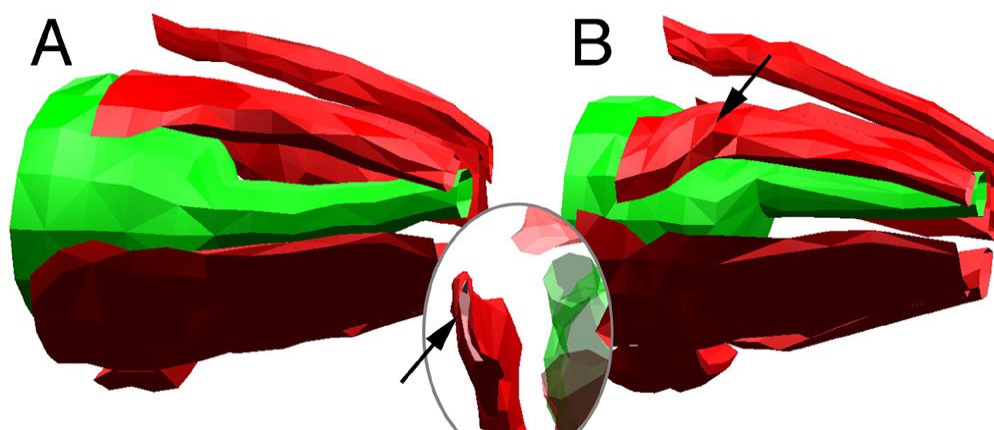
Patient TS, 3-D MRI reconstructions of extraocular muscle paths in primary gaze. A: Preoperative MRI scan shows left SO and left LR atrophy typical of chronic denervation. Note in inset, posterior view showing unusually thin LR. B: Postoperative MRI shows little lateral displacement of SR and IR belly (not shown in this view), with marked path inflections (arrow to SR) as muscles course through pulleys to their transposed insertions.
